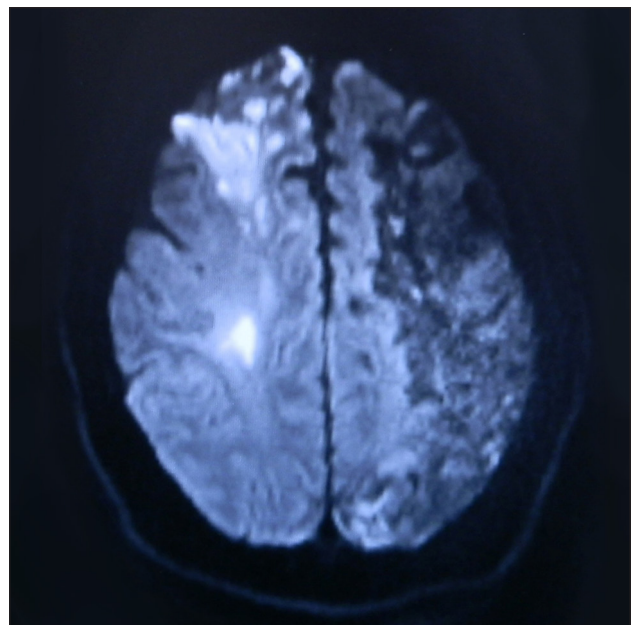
Diffusion weighted magnetic resonance imaging on April 30 2010, demonstrating infarcts on right frontal lobe and parietal lobe
